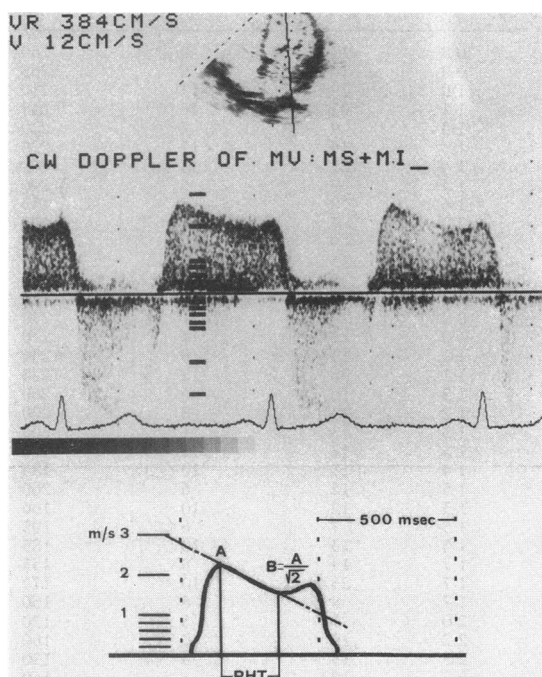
(Top) Transmitral flow velocity curve obtained by continuous wave Doppler from the apical approach. (The solid line within the echocardiographic image is the Doppler beam.) (Middle) Flow velocity profile; flow below the zero line in systole indicates mitral regurgitation. The first 5 bars above and below the zero line represent calibration of 0.2 m/s and the next bars represent 1 m/s. (Bottom) Method for obtaining transmitral pressure half time (PHT). A, peak velocity; B, half peak pressure.
